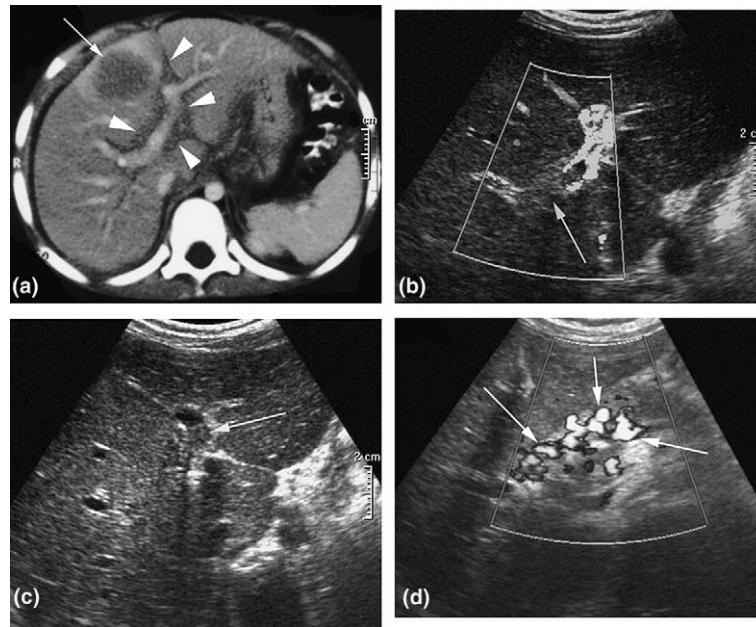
7-year-old boy with Murphy stage III abdominal Burkitt's lymphoma (patient No. 1). Initial post-contrast computerised tomographic (CT)-scan (a) shows intrahepatic location (arrow) and peritoneal lymphomatous involvement extended into the recess of ligamentum teres (arrowheads), encasing the two main portal branches, still permeable. Power Doppler US after COPAdM2 (b) shows a complete abdominal response, but a right main portal branch thrombosis (arrow) without any clinical, laboratory or ultrasound sign of HVOD. Power Doppler US after CyM1 (c–d) shows extension of the thrombosis (arrow) to the left portal branch (c) and occurrence of a hilar cavernoma (arrows) (d) hence the patient received isocoagulant heparin therapy. 39 months after the end of treatment, the child is still in first complete remission, but presents persistent cavernoma associated with signs of chronic PHT.
